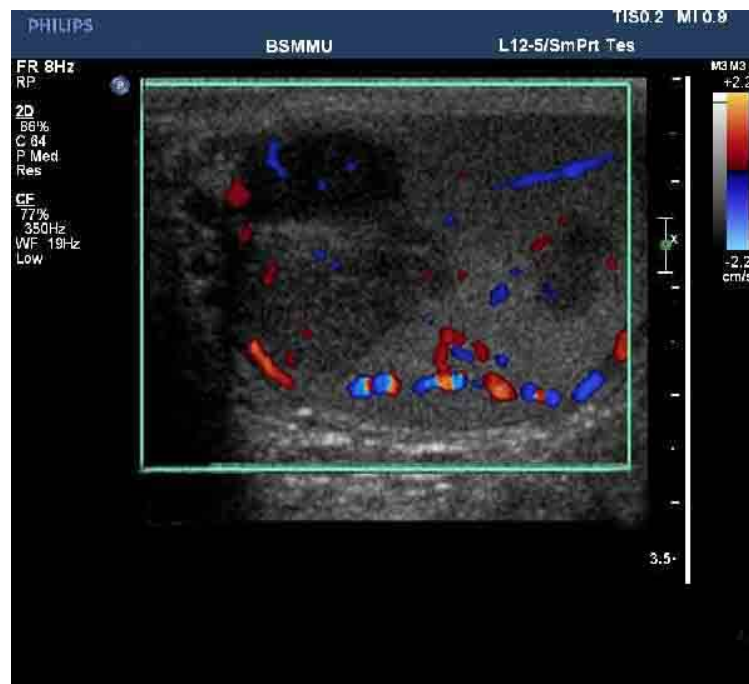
Testicular Seminoma-Color Doppler scan showing multiple hypoechoic testicular lesions with increased vascularity.
